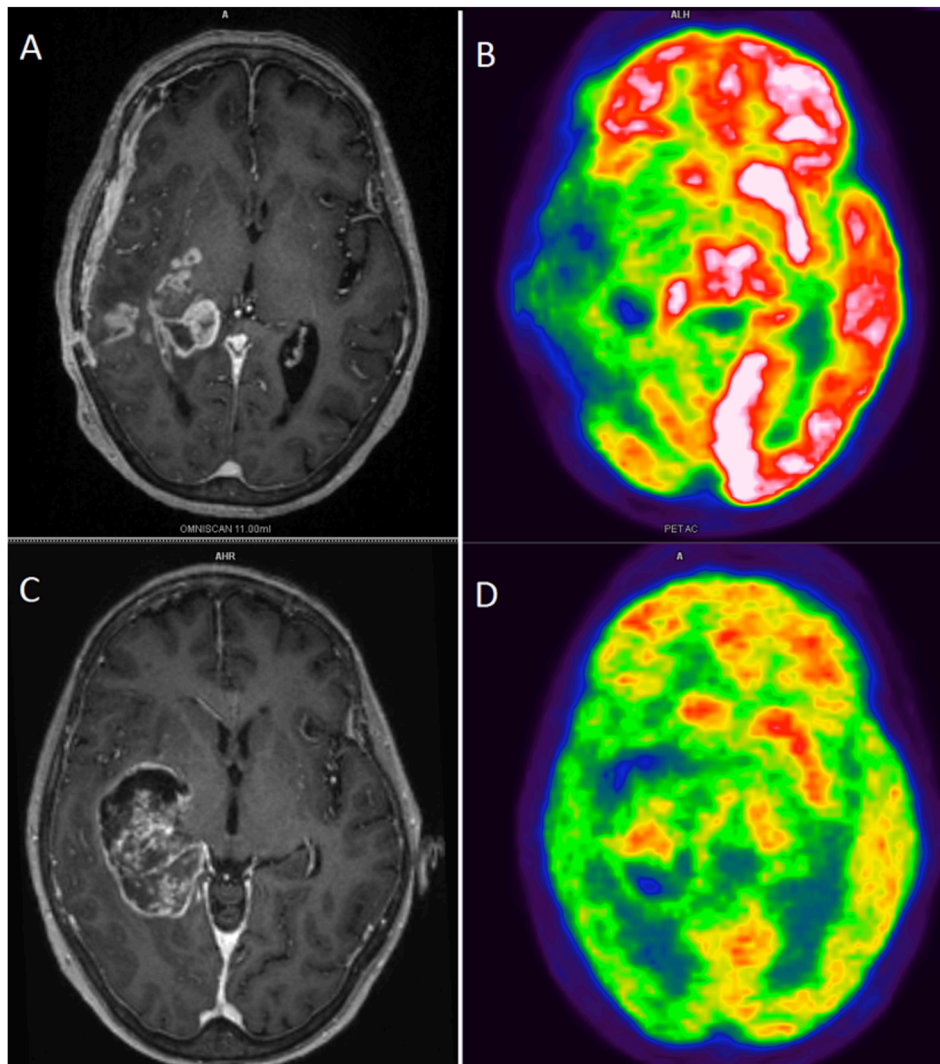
An example of PET/MRI before (C and D) and after (A and B) surgical intervention. It is possible to appreciate the growth in aMRGlu, especially in the contralateral hemisphere.
